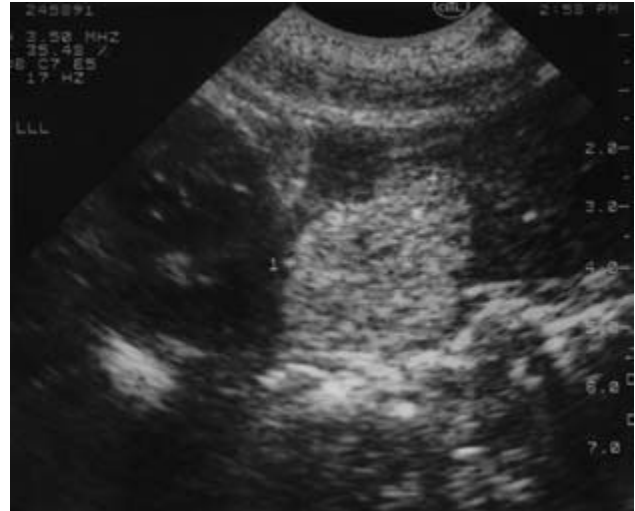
Ultrasonography showing a 3-cm hyperechoic mass in the liver. This is characteristic of a cavernous haemangioma.
